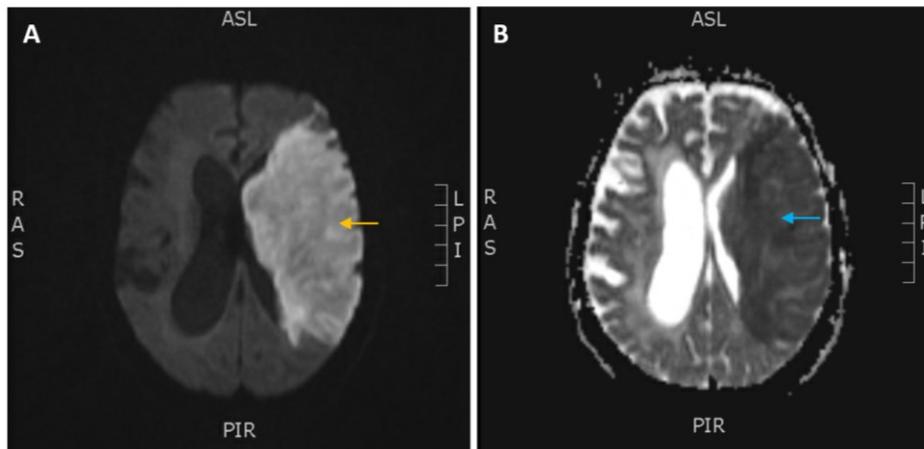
Infarct on MRI. MRI- brain showing left sided Middle Cerebral Artery infarct. A: Diffusion-Weighted (yellow arrow). B: Apparent Diffusion Coefficient (blue arrow).
